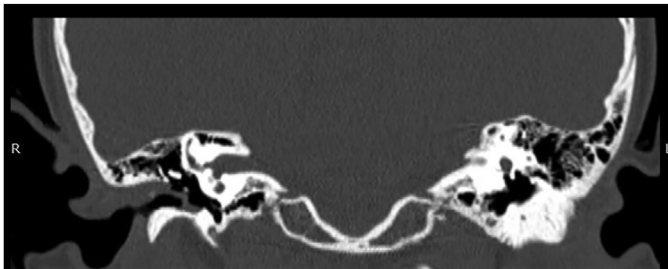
Coronal CT showing right ear with ASEEC and normal middle ear space.
